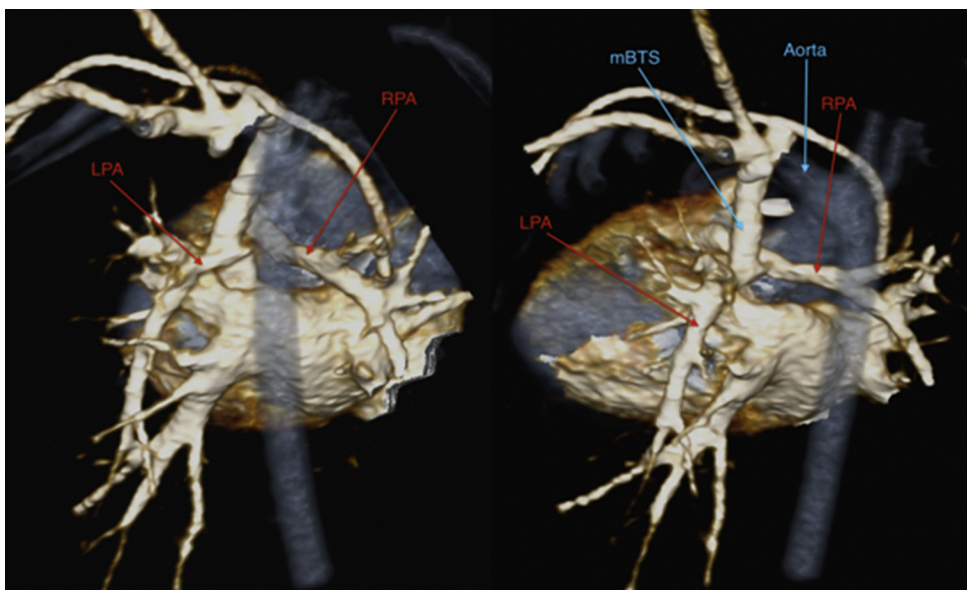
Postoperative anatomy by computed tomographic angiography. mBTS = modified Blalock–Taussig shunt; LPA = left pulmonary artery; RPA = right pulmonary artery.
